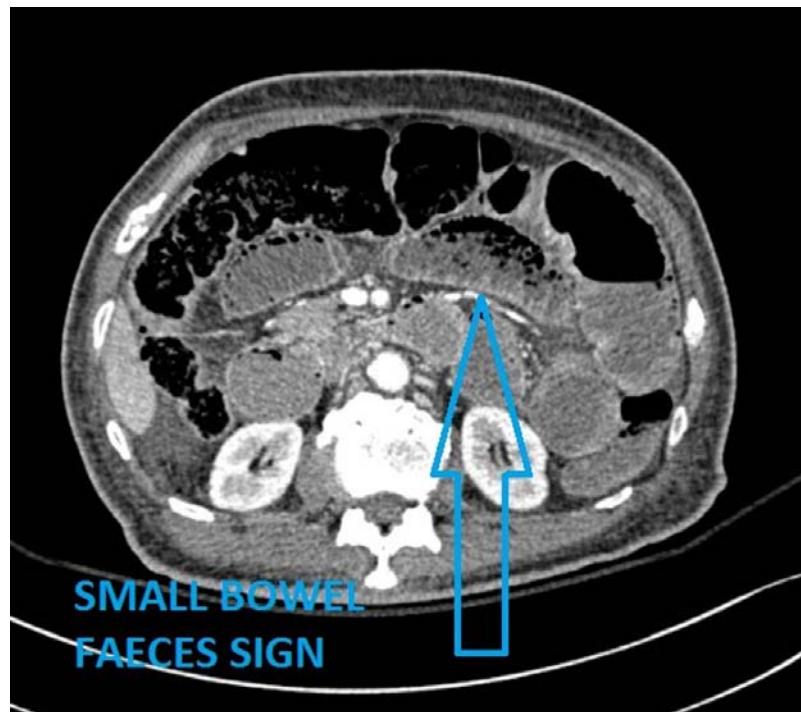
Axial abdominal CT showing small bowel feces sign (blue arrow) [62]
